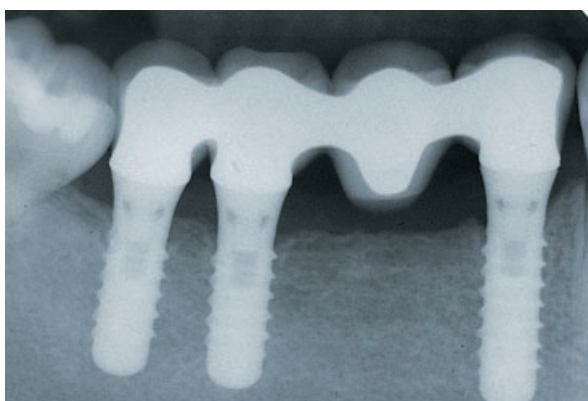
The radiographic control confirms both successful osseointegration of the involved implants and accurate marginal adaptation of the suprastructure.
